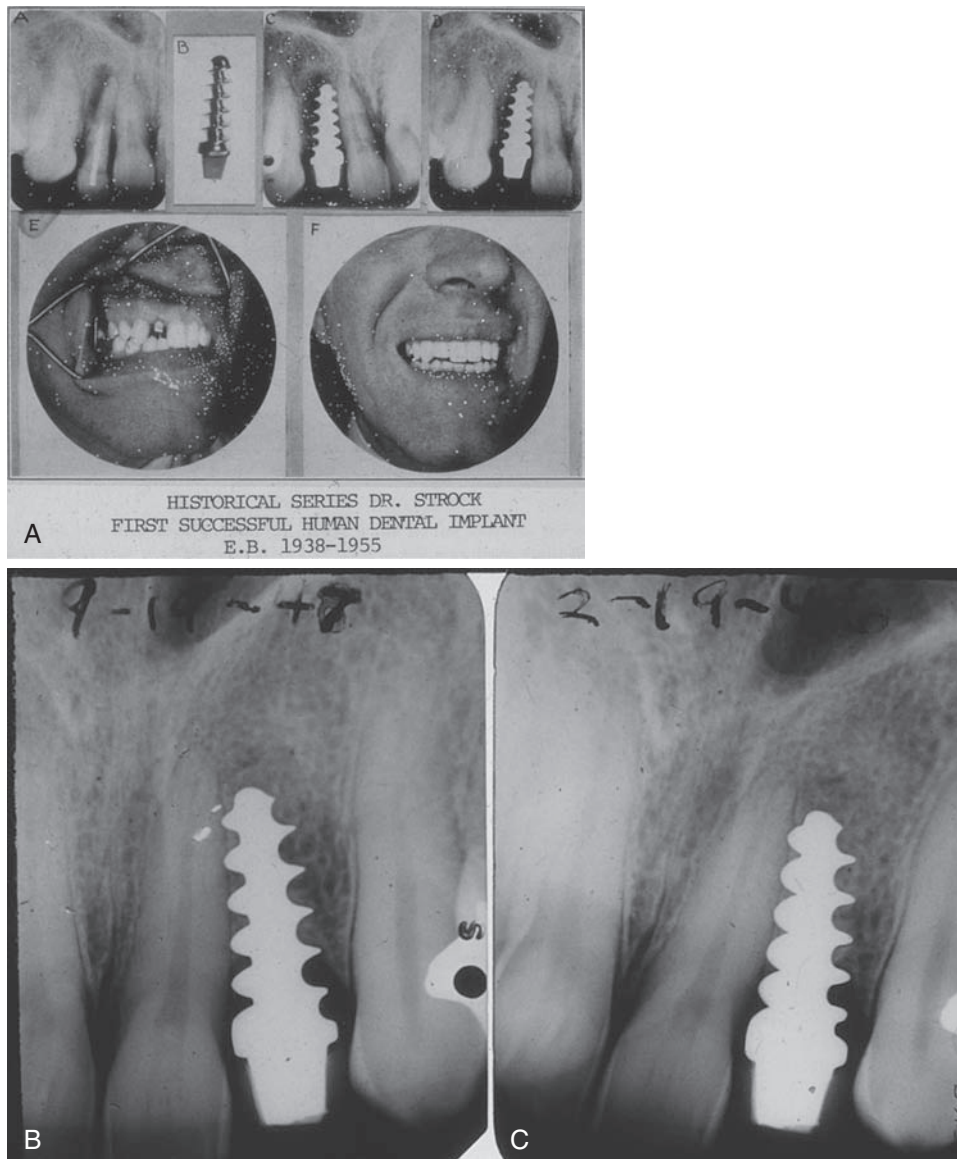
A, The first extraction and placement of endosseous bone screw followed by dental restoration. Periapical x-rays taken at 8 years (B) and 9 years (C) postrestoration. (From Rosenlicht JL, Ward J, Krauser JT: Impressions at surgical placement and provisionalization of implants. In Fonseca RJ, et al, editors: Oral and maxillofacial surgery, vol 1, St Louis, 2009, Elsevier.)
